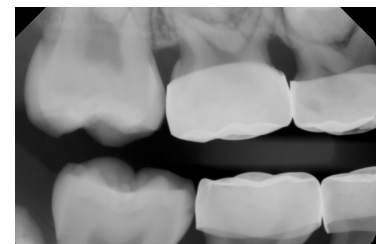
8/2014 radiograph.
